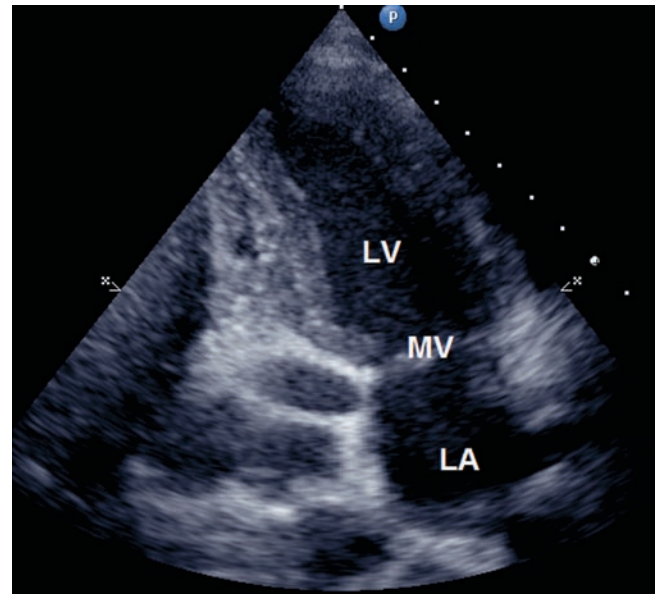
Apical 2-chamber view. *LA* left atrium; *LV* left ventricle; *MV* mitral valve
